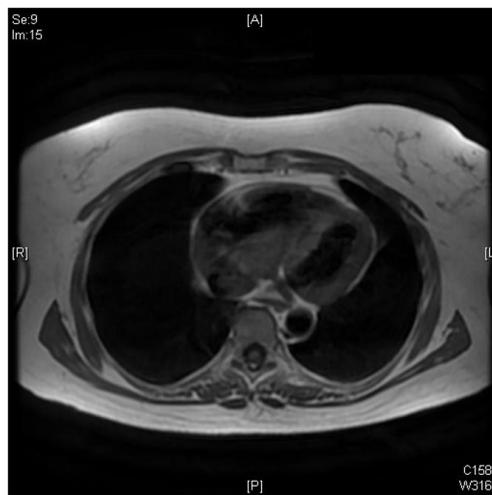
Cardiac magnetic resonance imaging shows intracardiac mass exhibiting the same density as adjacent cardiac tissues.
